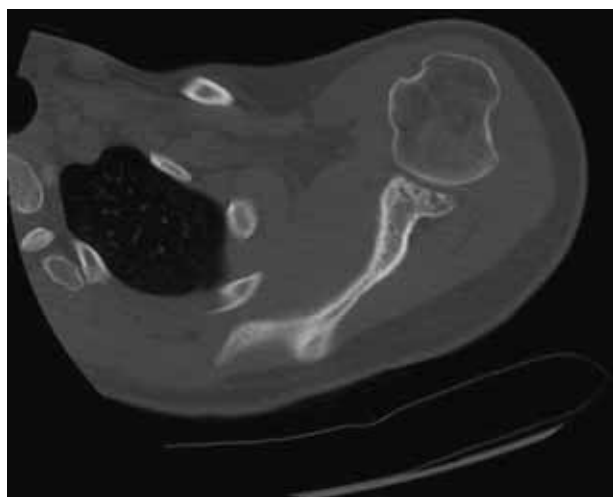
Axial computed tomography image of the left shoulder showing anterior glenoid bone loss in addition to a large Hill-Sachs defect on the humeral head.
